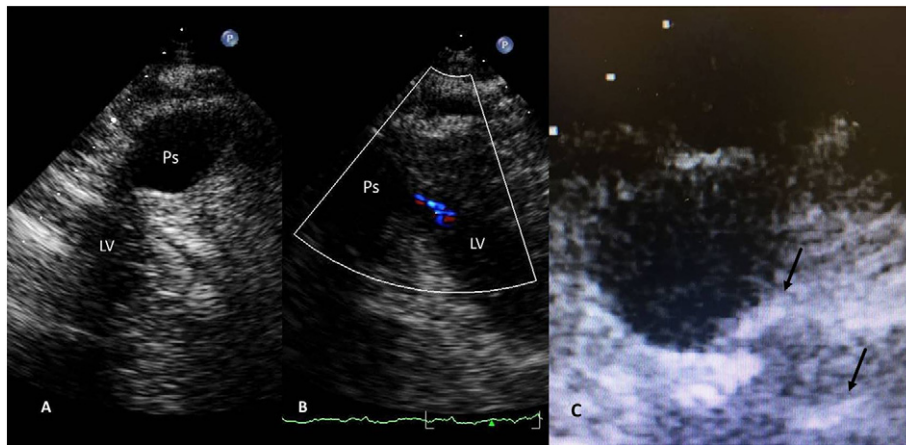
Transthoracic echocardiography shows in Panels A and B the pseudoaneurysm (Ps) cavity with the forward and back flow at the Colour-Doppler. Panel C. Transthoracic echocardiography at one year follow up from the procedure. The pseudoaneurysm cavity is completely thrombosed. Black arrows shows the Amplatzer Vascular Plug 4 discs.
